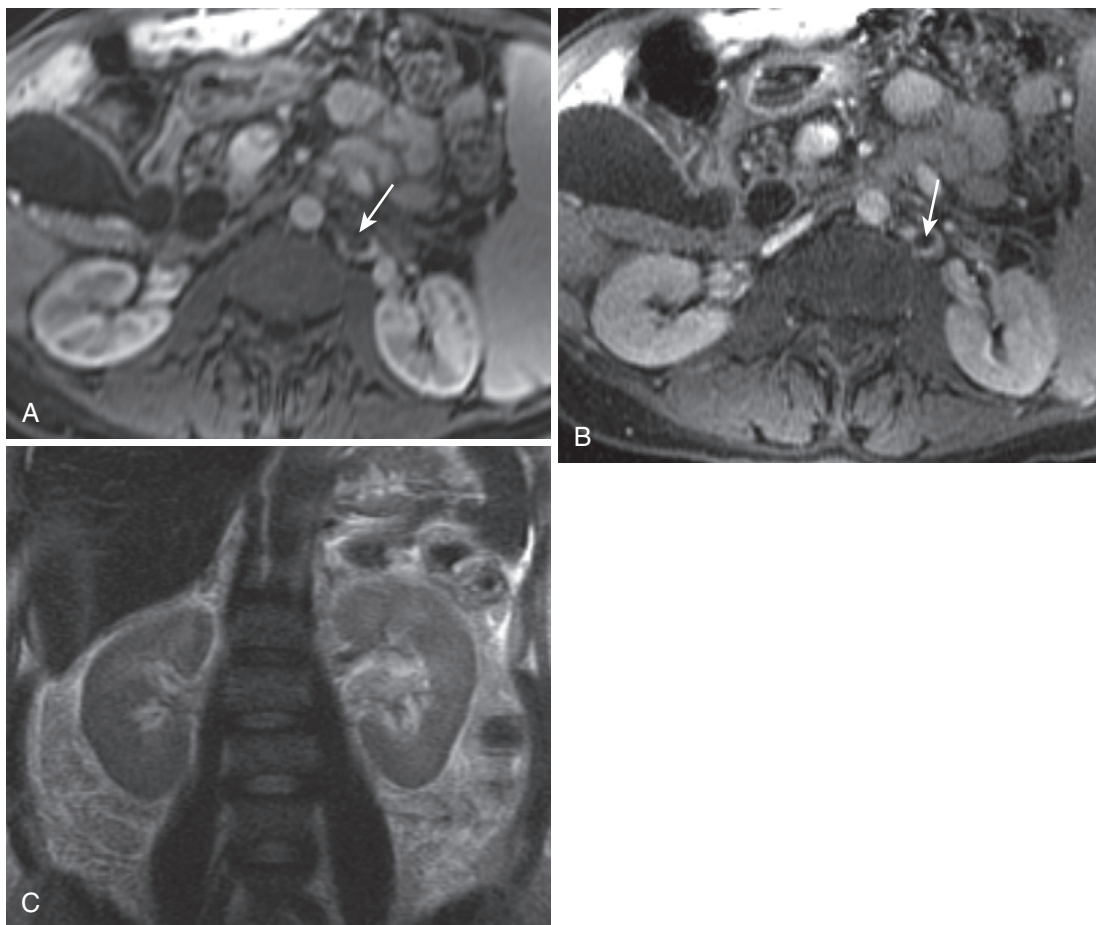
Renal vein thrombosis. The early (A) and delayed (B) postcontrast images demonstrate an at least nearly complete occlusive filling defect in the left renal vein (*arrow*). The coronal T2-weighted image (C) shows subtle left renal enlargement.
